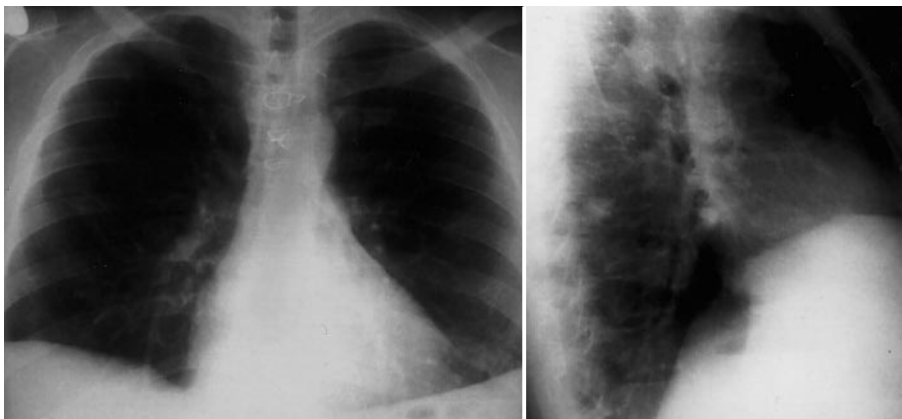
Case 1. Chest radiograph in May 1995, 4 years after operation showing that all the nodules have disappeared
